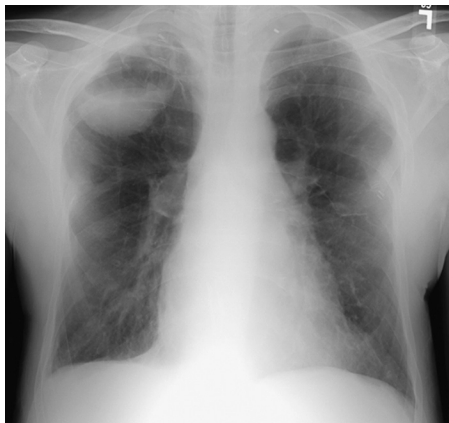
Invasive aspergillosis. Large right upper lobe cavity containing an air-fluid level. Transthoracic needle biopsy demonstrated fungal elements morphologically consistent with *Aspergillus* species. (From Mason RJ. Murray and Nadel's Textbook of Respiratory Medicine. 5th ed. Philadelphia: Saunders, 2010, Fig. 95-3.)
